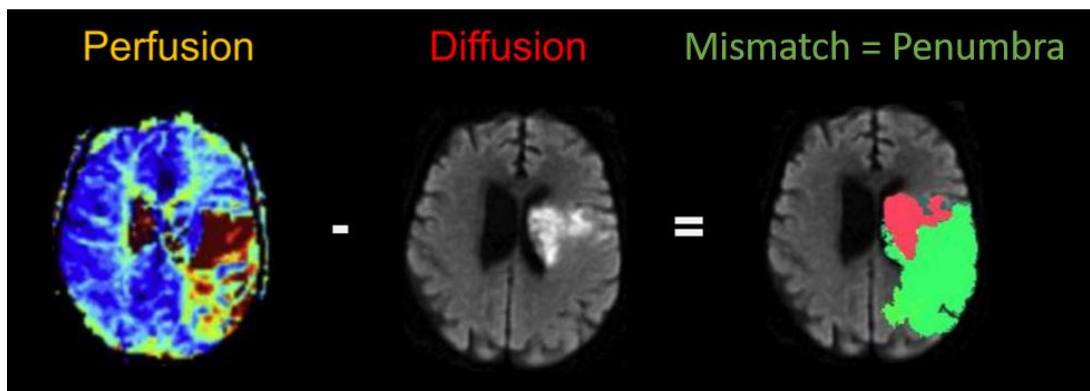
The penumbra can be seen with the mismatch of perfusion and diffusion weighted MRI images (From Moskowitz et al., 2010).
